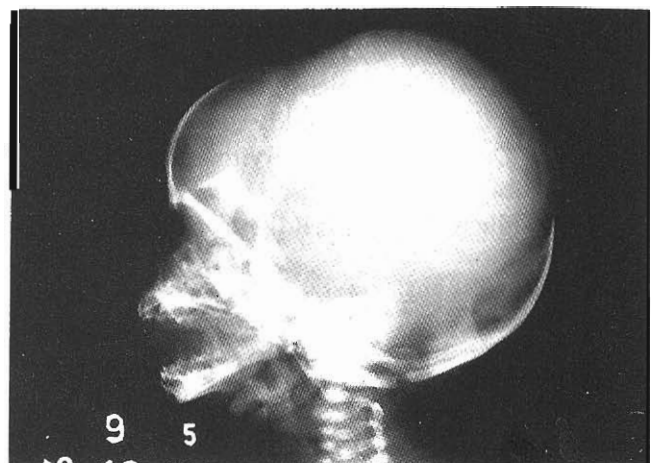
X-ray of the skull showing the narrowing of the bones with protrusion of brain tissue.
